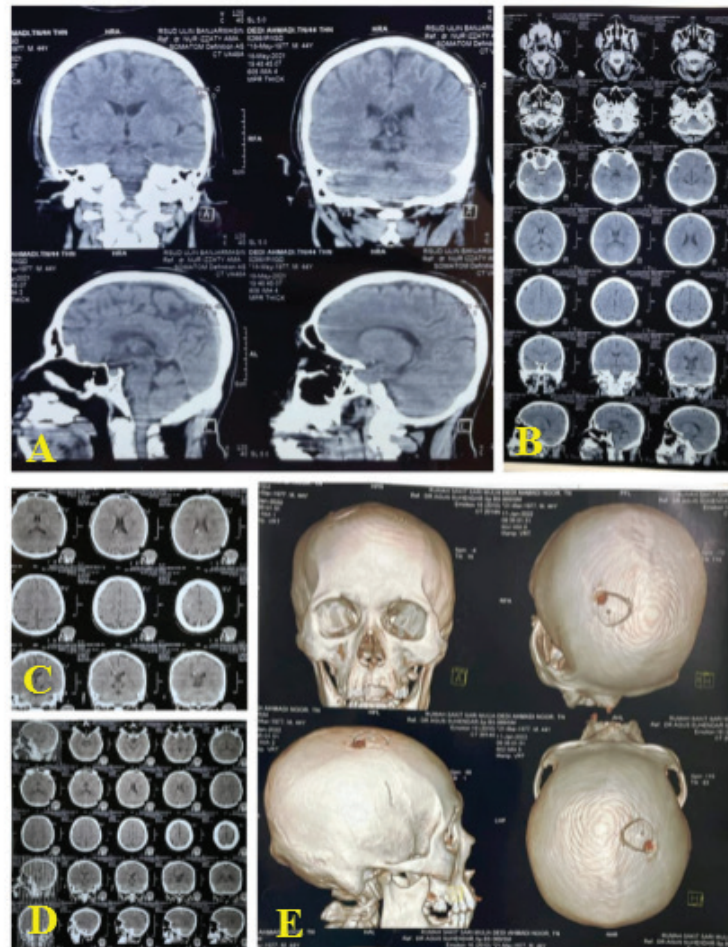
Patient Head CT Scan Post Operation (A-E)
